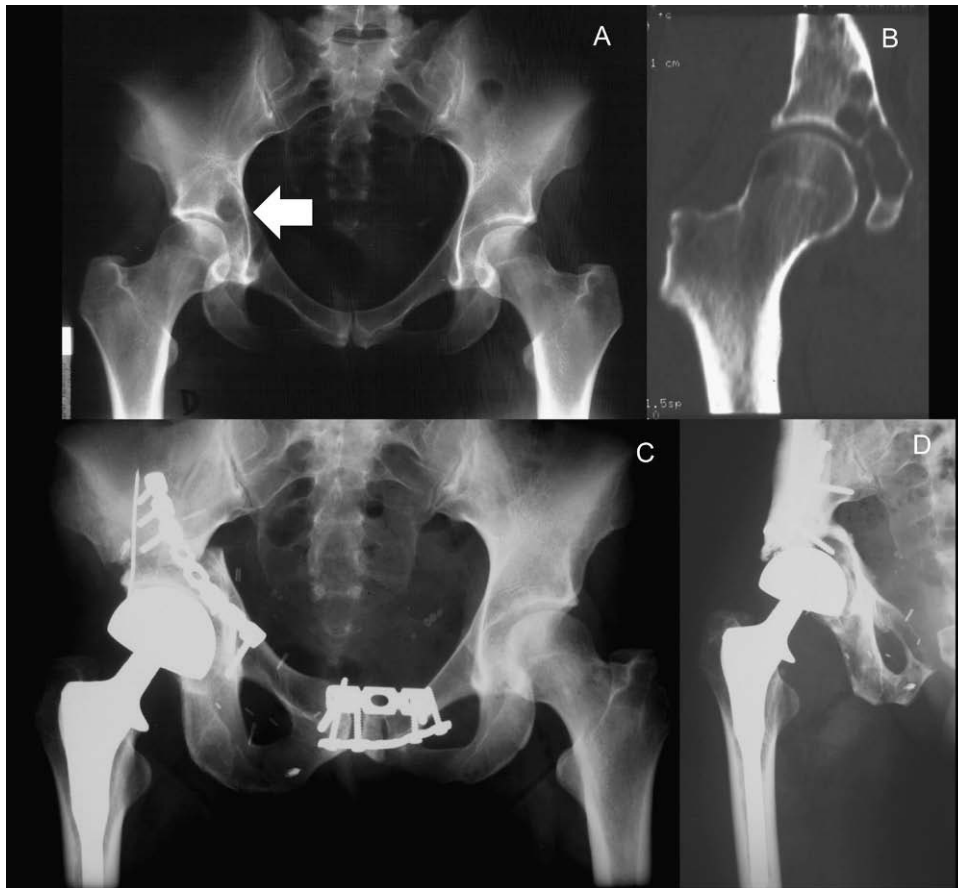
A) Plain film prior to the pelvic lesion in the patient described in Case 2. B) Computerized tomographic view. C) X-ray of the patient described in Case 2 following resection of areas ii and iii of the right hemipelvis that shows the reconstruction with bone bank allograft and a bipolar prosthesis. D) Radiograph taken following the surgery at which the iliopsoas muscle was ruptured. Note the result obtained following resection of area i and emergency stabilization with polymethylmetacrylate and screws.
